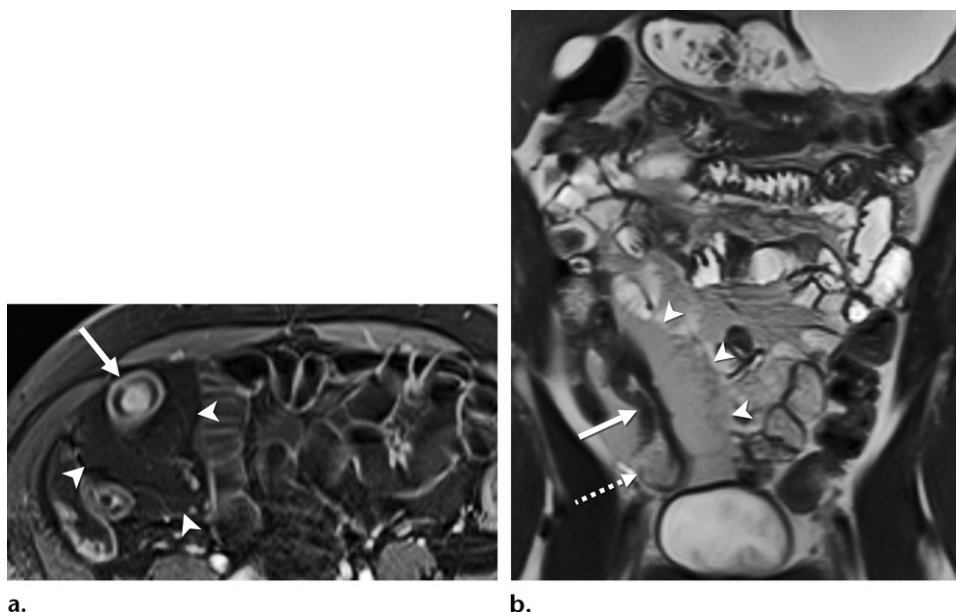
Fibrofatty proliferation in two patients with Crohn disease. (a) Axial contrast-enhanced fat-suppressed T1-weighted MR enterographic image with biphasic oral contrast material shows circumferential fibrofatty proliferation (arrowheads) adjacent to a thick-walled inflamed small bowel segment that has stratified (trilaminar) mural hyperenhancement (arrow). (b) Coronal T2-weighted MR enterographic image with biphasic oral contrast material shows eccentric fibrofatty proliferation (arrowheads) adjacent to a thick-walled small bowel segment (solid arrow) with luminal narrowing and mild upstream bowel dilation (dashed arrow), consistent with a stricture with active inflammation.
